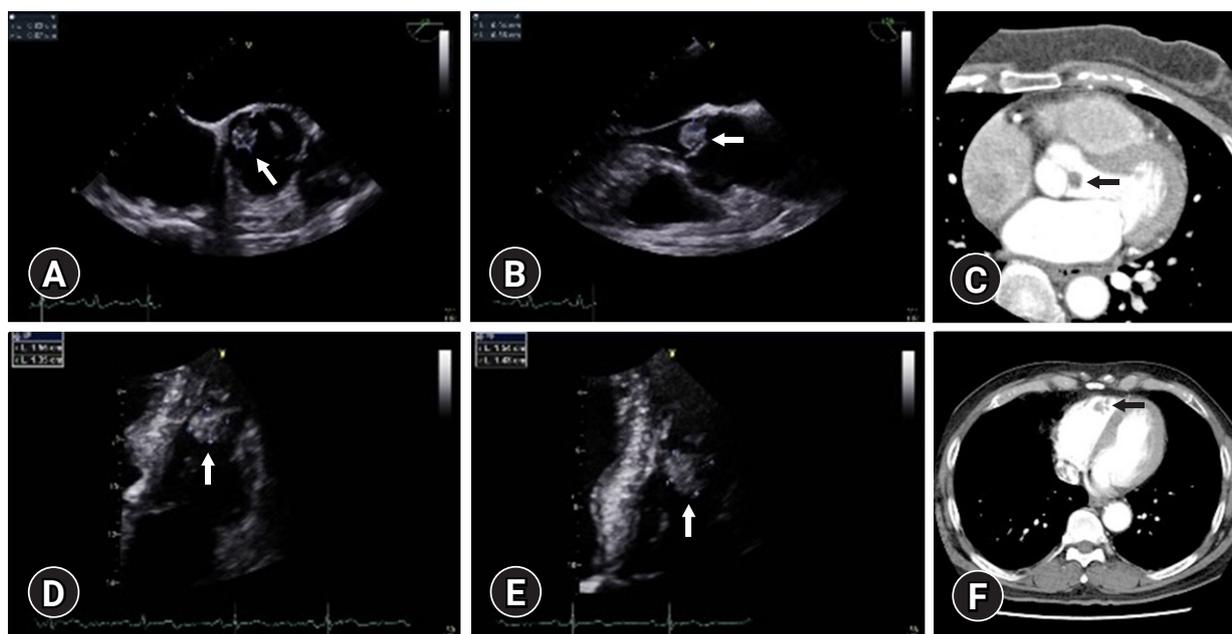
Radiological findings of case 1 (A–C) and case 2 (D–F). (A, B) Preoperative echocardiography shows a mobile mass (arrow) on the ventricular surface of the noncoronary cusp of the aortic valve. (C) Computed tomography image shows a mass lesion (arrow) on the aortic valve. (D, E) Preoperative echocardiography shows a round mass (arrow) in the right ventricle. (F) Computed tomography shows a mass lesion in the right ventricle (arrow).
